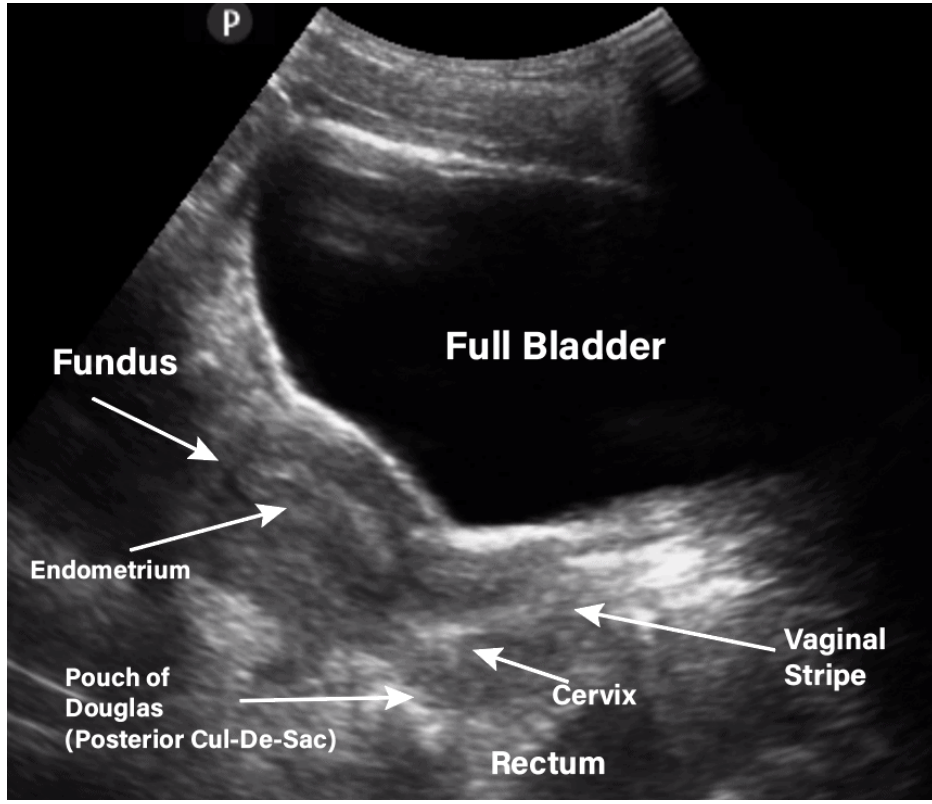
Transabdominal Pelvic Ultrasound a Longitudinal View of Female Pelvic Anatomy adopted form Ujaddughe O et al., 2024
